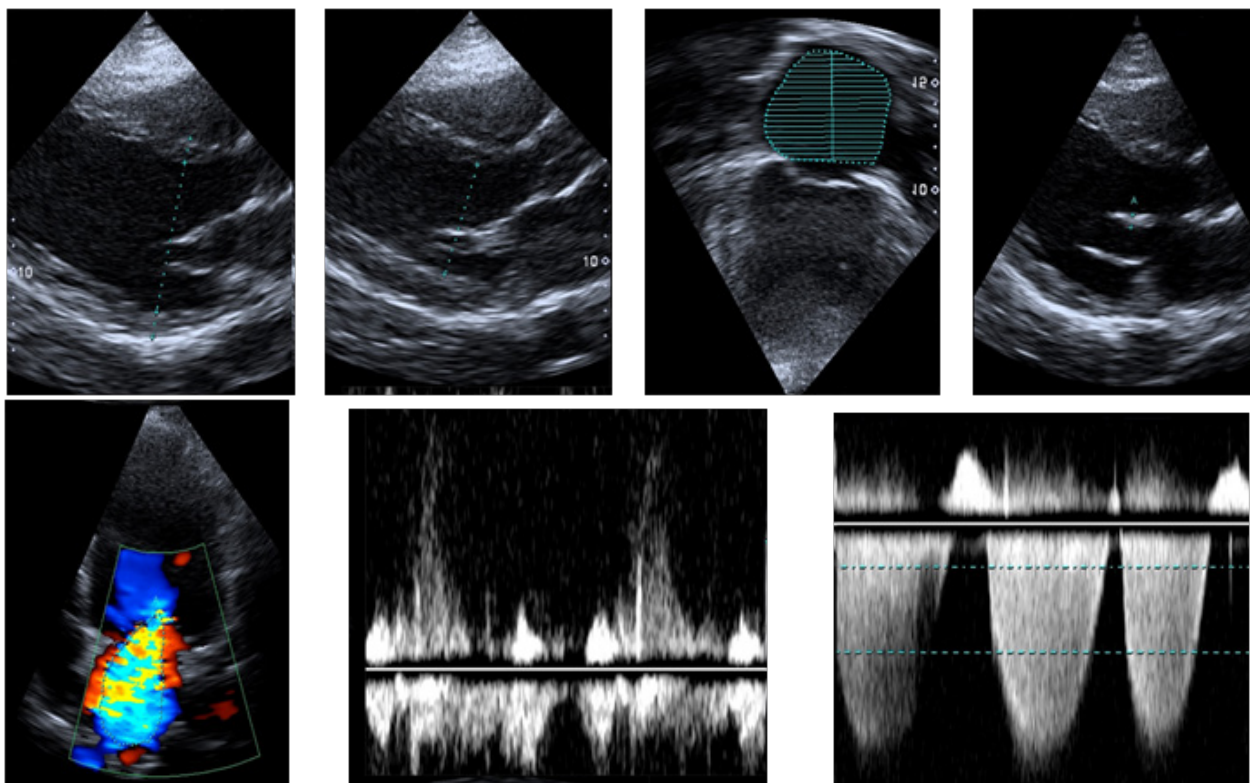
Echocardiographic images representing, on the superior row from left to right: left ventricular diastolic diameter, left ventricular systolic diameter, left atrial volume and mitral valve thickening. On the inferior row: 4-chamber color doppler showing important mitral regurgitation; continuous-wave doppler from pre and post-ARF mitral regurgitation
